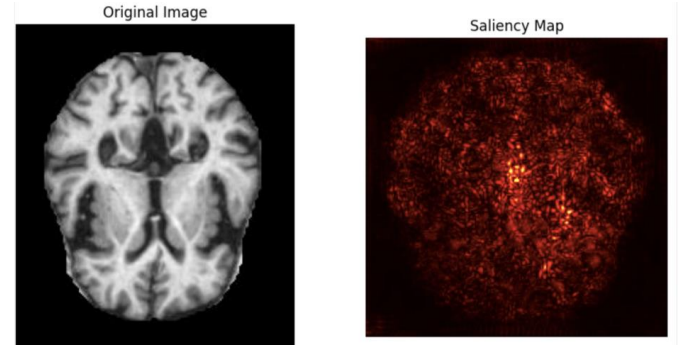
Original MRI scan of Alzheimer's Disease and the Saliency Map from the Pre-trained Model VGG16
